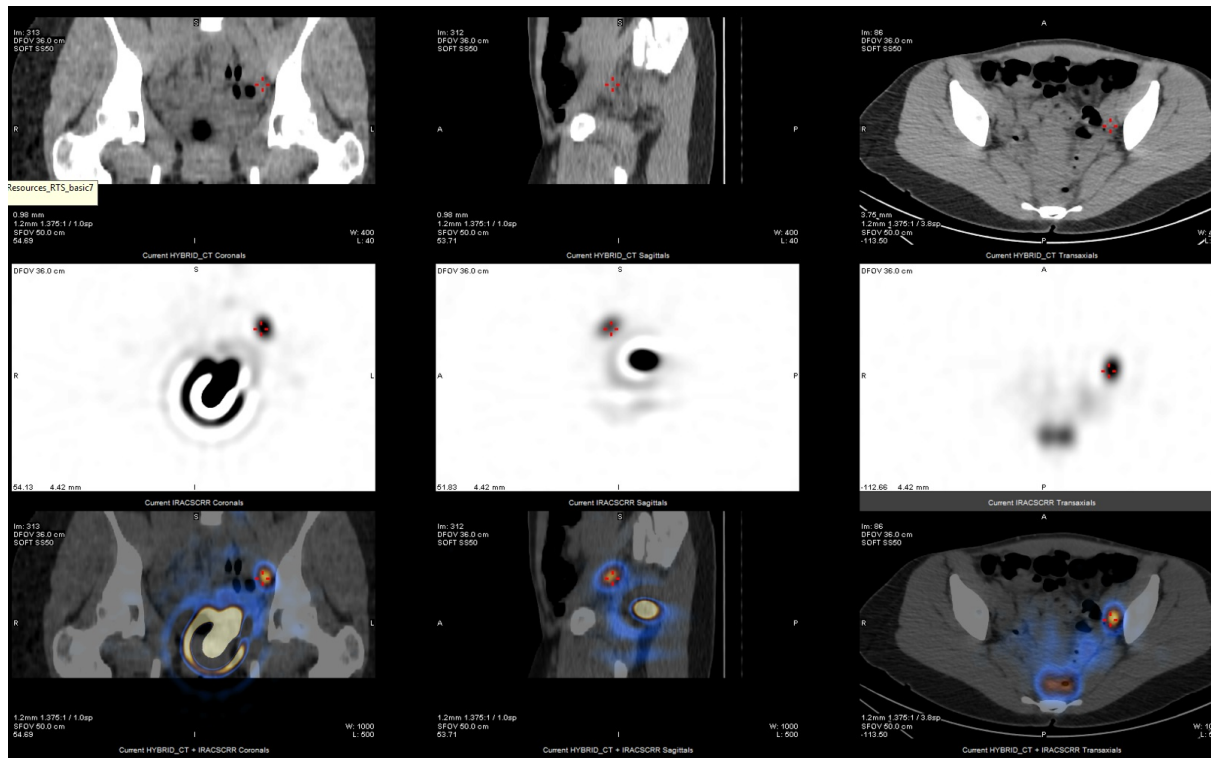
Planar and SPECT-CT imaging over coronal, sagittal and axial planes demonstrate the transit of the radioisotope from the injection site at the lower rectum to the left pelvic side wall in Patient 13, with the crosshairs indicating focal LN uptake in that region.
